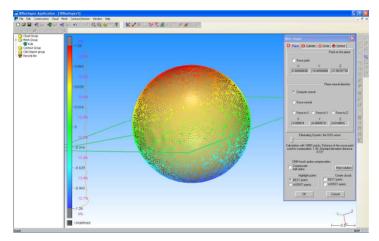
Map of the distribution of measurement points and their distance from the equatorial plane of the reference ball as the result of measurement on CT.
